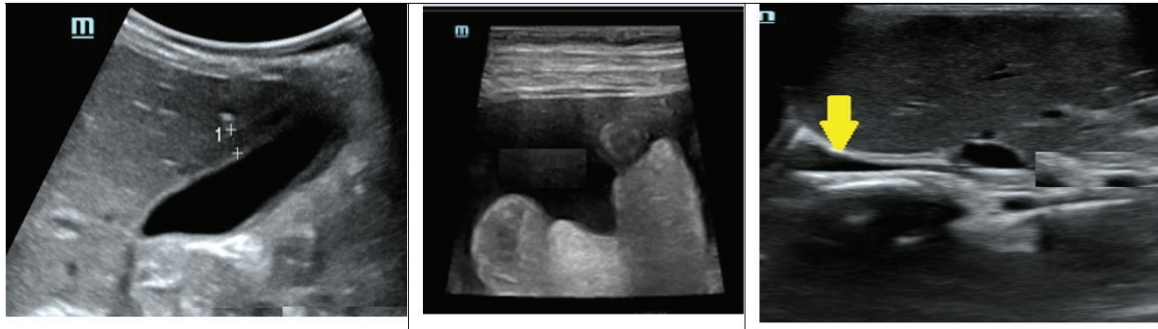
Common Ultrasound Abnormalities In Patients with Dengue Include Thickened Gall Bladder Wall (Gall Bladder wall edema) (Left), Ascites in the form of Free Fluid in Peritoneal Cavity (Middle) and Right Pleural Effusion (Right)
